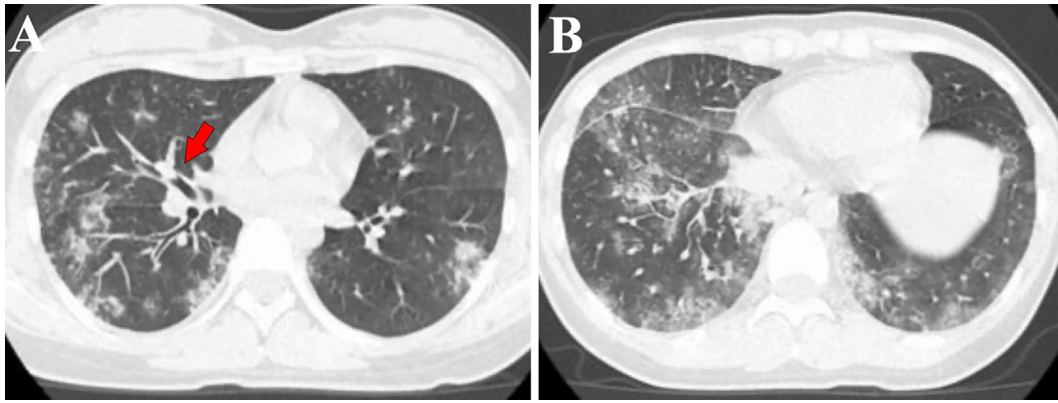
Ground-glass opacities with bronchial wall thickening (indicated by a red arrow). (A) Lobular central granular shadows and (B) computed tomography findings of the chest.
